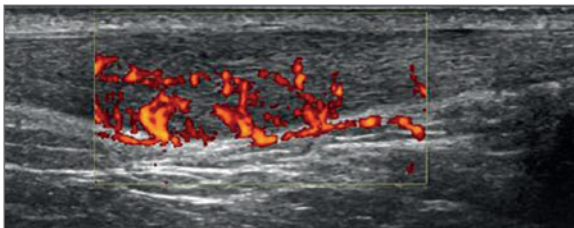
Longitudinal image of the Achilles tendon. In addition to a marked fusiform swelling within the midsubstance of the tendon, Power Doppler demonstrates a significant neovascularity throughout the tendon imaged.
